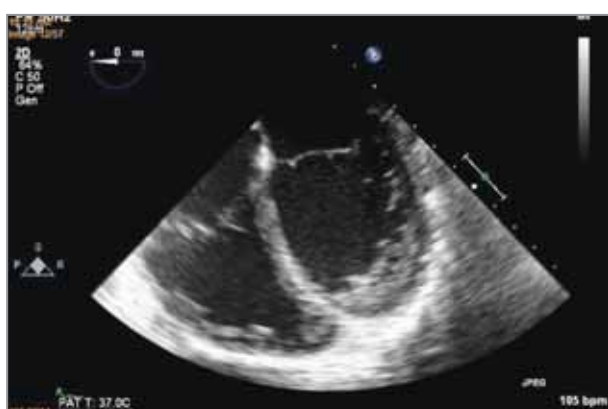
Echocardiography of Case 2. Short-axis view showing trabeculations in the left ventricular wall, with inter-trabecular recesses in continuation with the left ventricular cavity.
